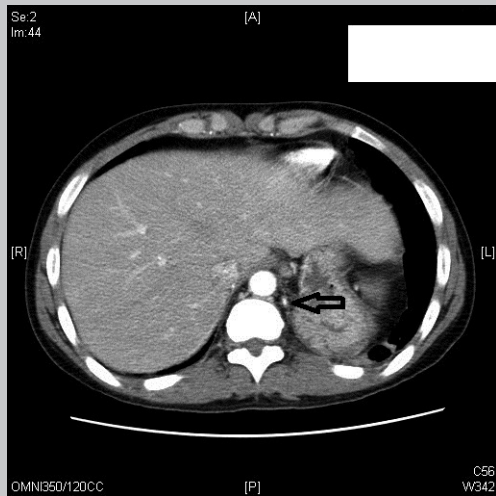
Computed tomography scan of chest and abdomen showing the artery now in the lung parenchyma.
